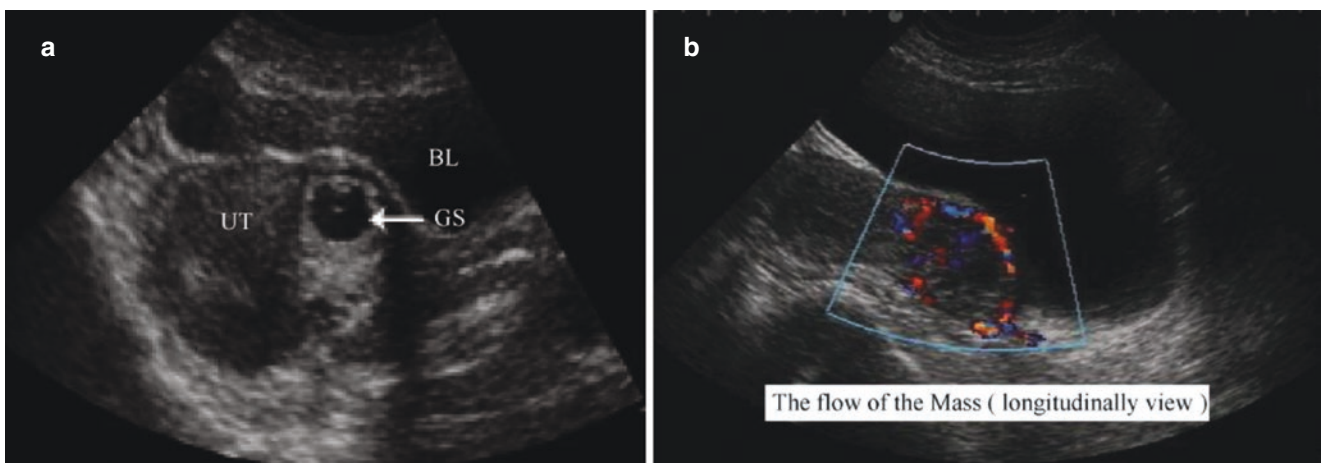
Isthmic ectopic pregnancy. (a). After 43 days of amenorrhea, there is no gestational sac in the uterus, and the gestational sac is found in the isthmus of uterus; (b). Color Doppler shows the circular blood flow around the ectopic pregnancy in the uterine isthmus
